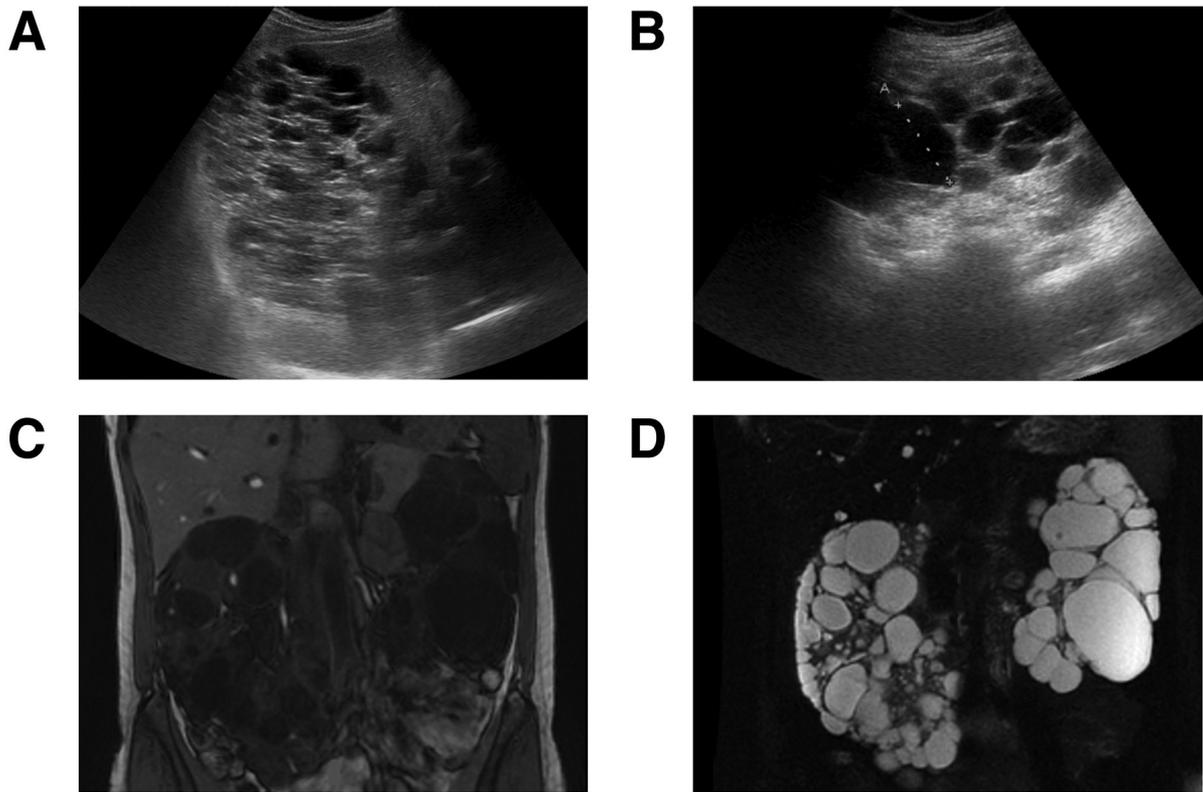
Imaging of ADPKD using renal US (Panels A & B) and MRI (Panels C & D). ADPKD=autosomal dominant polycystic kidney disease; MRI = magnetic resonance imaging; US = ultrasound.
